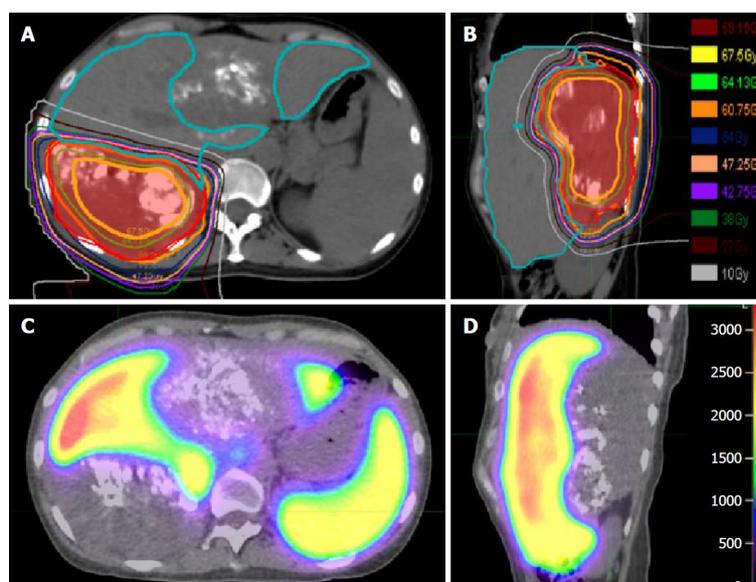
Radiation therapy approach. A, B: Proton radiation therapy treatment using a 2-beam approach for the treatment of the right-sided hepatocellular carcinoma highlighting low dose to the contralateral lobe of the liver; C, D: Demonstrated functional liver imaging using technetium-99m sulfur colloid single-photon emission computerized tomography scan co-registered to the radiation therapy planning computed tomography to aid in target delineation of the gross tumor volume and sparing of the highly functional liver (max sulfur colloid single-photon emission counts shown in red). Key: Liver minus gross tumor volume is demonstrated by the teal line (panels A, B), internal target volume (gross tumor volume + tumor motion on 4D-computed tomography scan) is shaded in red (panels A, B).
